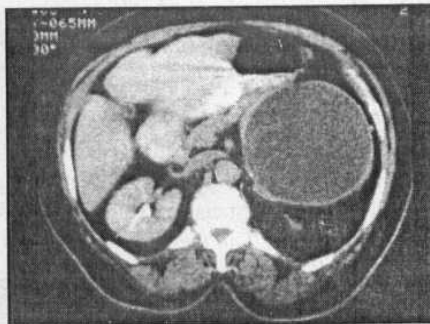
Mesenteric hydatid cyst seen by CT only.
